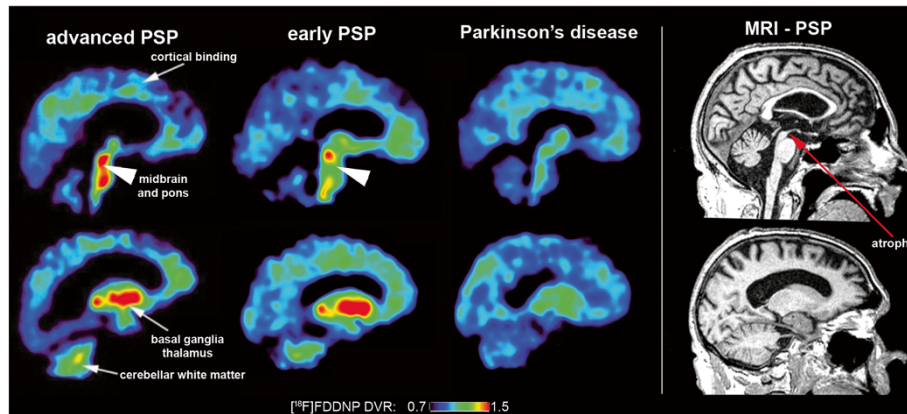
Tau ligand binding patterns in progressive supranuclear palsy. (Left) Typical 2-(1-(6-((2-[¹⁸F]fluoroethyl)(methyl)amino)-2-naphthyl) ethylidene) malononitrile ([¹⁸F]-FDDNP) binding patterns seen in advanced progressive supranuclear palsy (PSP), early PSP and Parkinson's disease. [¹⁸F]-FDDNP signal due to tau binding seen in the basal ganglia, midbrain and pons in PSP subjects but not in Parkinson's disease. (Right) Sagittal magnetic resonance imaging (MRI) scan of a PSP patient with characteristic midbrain atrophy. DVR, distribution volume ratio, a scaled measure that indicates the linear function of radioligand binding. Reprinted with permission from [98].
